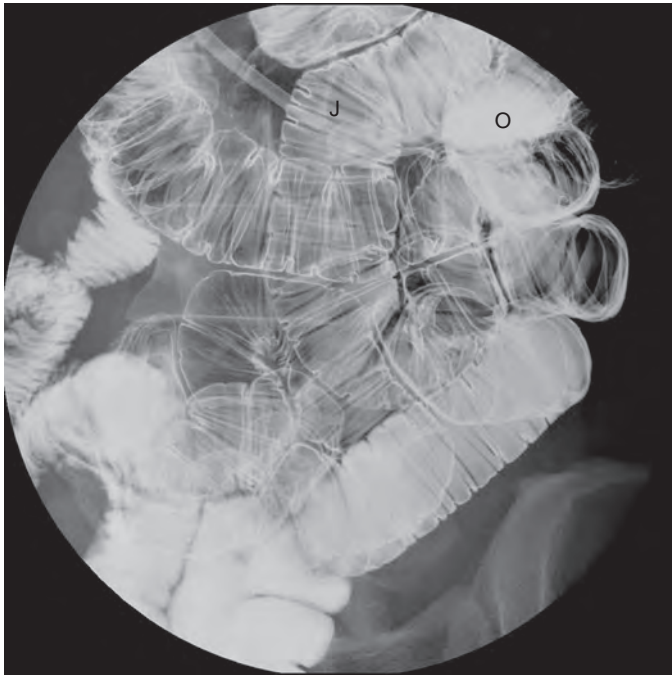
Jejunum during air-contrast enteroclysis. Coned-down view from an overhead radiograph demonstrates the small intestine in an air-contrast study. The jejunum (J) is well shown where loops are seen without overlap. When loops overlap (O), however, the small bowel is not optimally visualized.
